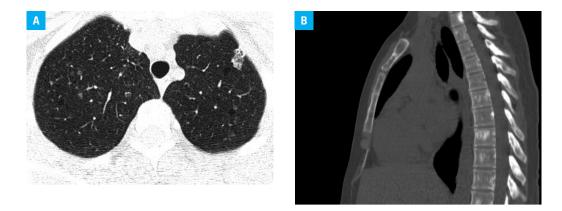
A – thin-section axial computed tomography image (lung window) showing numerous bilateral small ground-glass nodules and smaller diffuse, rounded, thin-walled lung cysts; B – sagittal computed tomography image showing multiple sclerotic bone lesions of the thoracic and cervical spine vertebral bodies and sternum
